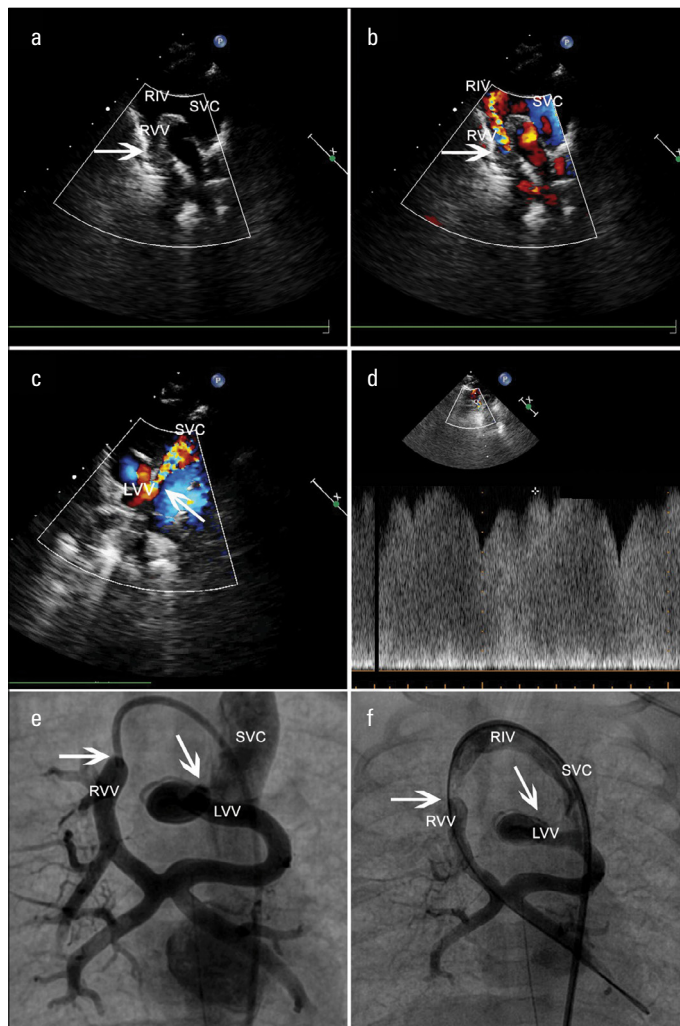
a-f. (a, b) Suprasternal echocardiographic 2-D and colored Doppler views demonstrating the continuation of the right vertical vein (RVV) draining into the right innominate vein (RIV), which in turn drains into the left-sided superior caval vein (SVC). White arrows point out the obstruction sites. (c) Suprasternal echocardiographic colored Doppler view demonstrating the left vertical vein (LVV) draining into the left-sided superior caval vein (SVC). White arrows point out the obstruction sites. (d) The pulse-wave Doppler gradient (30 mm Hg) from the obstruction site. (e, f) The anteroposterior contrast injections to the right vertical vein (RVV) demonstrating the merging of the right and left pulmonary veins forming an X figure behind the left atrium and drainage of RVV to RIV and the tortuous LVV to the left-sided SVC. White arrows point out the obstruction sites.
